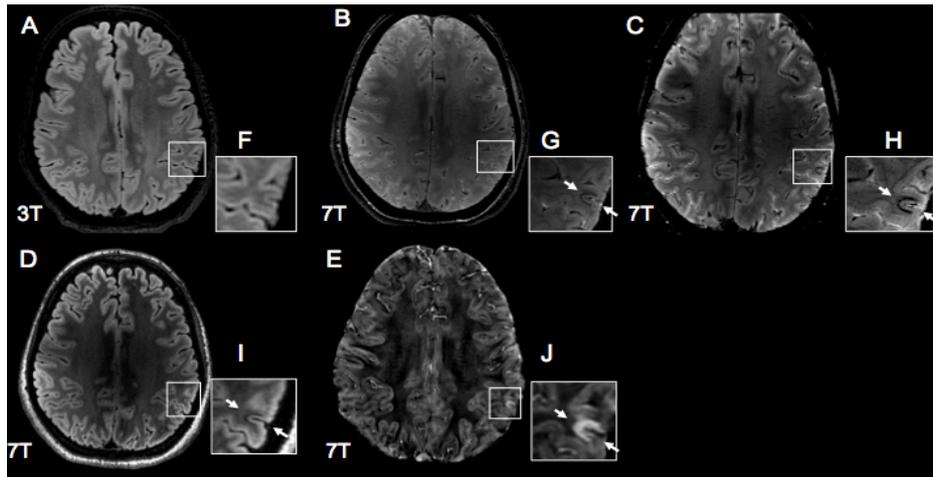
3T and 7T images, with 7T magnetic susceptibility map in a patient with intractable focal epilepsy. (Patient 21). The top row shows 3T axial 3D FLAIR (A), 7T axial 3D SWAN (B), 2D GRE (C), 3D FLAIR (D) images and 7T magnetic susceptibility map (E). The bottom row shows zoomed images of the boxed regions. Figure A and magnified image (F) reveal no structural abnormalities. Figure B-D discloses cortical thinning associated with a hypointense subcortical lamina in the left parietal lobe, characterized by along the grey-white matter interface (white arrows). Figures G-I, which are the magnifications of the boxed regions, enhance the detection of the epileptogenic lesion showing with high detail the reduced cortical thickness and hypointense line underlying the cortex (arrows). Of note, the lower resolution and contrast obtained enlarging 3T FLAIR image (F) compared to 7T zoomed images (G-I). Figure E and the magnified image J, show the magnetic susceptibility map in which a strong high signal intensity line (arrows) in the area concordant with the hypothesized SOZ, indicating different levels of paramagnetic substances with respect to the normal cortex.
